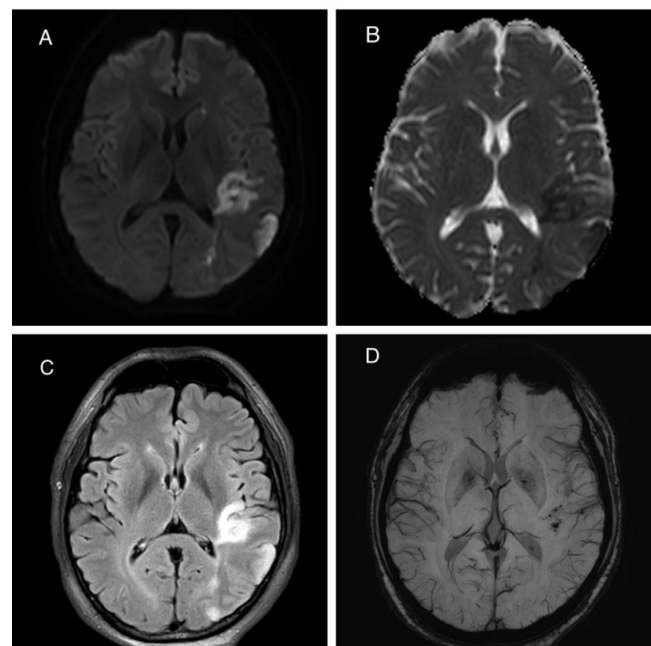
Repeated brain magnetic resonance imaging (MRI) on day 4 showing; A-B: The DWI and ADC map shows established infarct at the left temporo-parietal region. C: Corresponding matched abnormal high signal intensity is more conspicuous on the FLAIR sequence. D: Minimal microhaemorrhages are seen.
